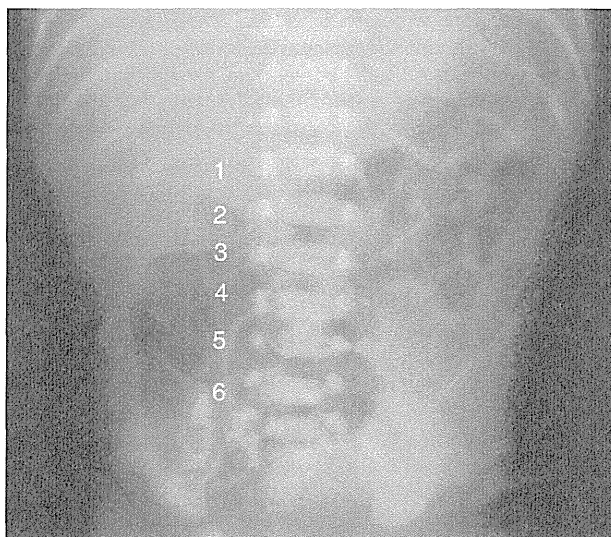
Abdominal X-ray of infant A revealed six lumbar vertebrae.
